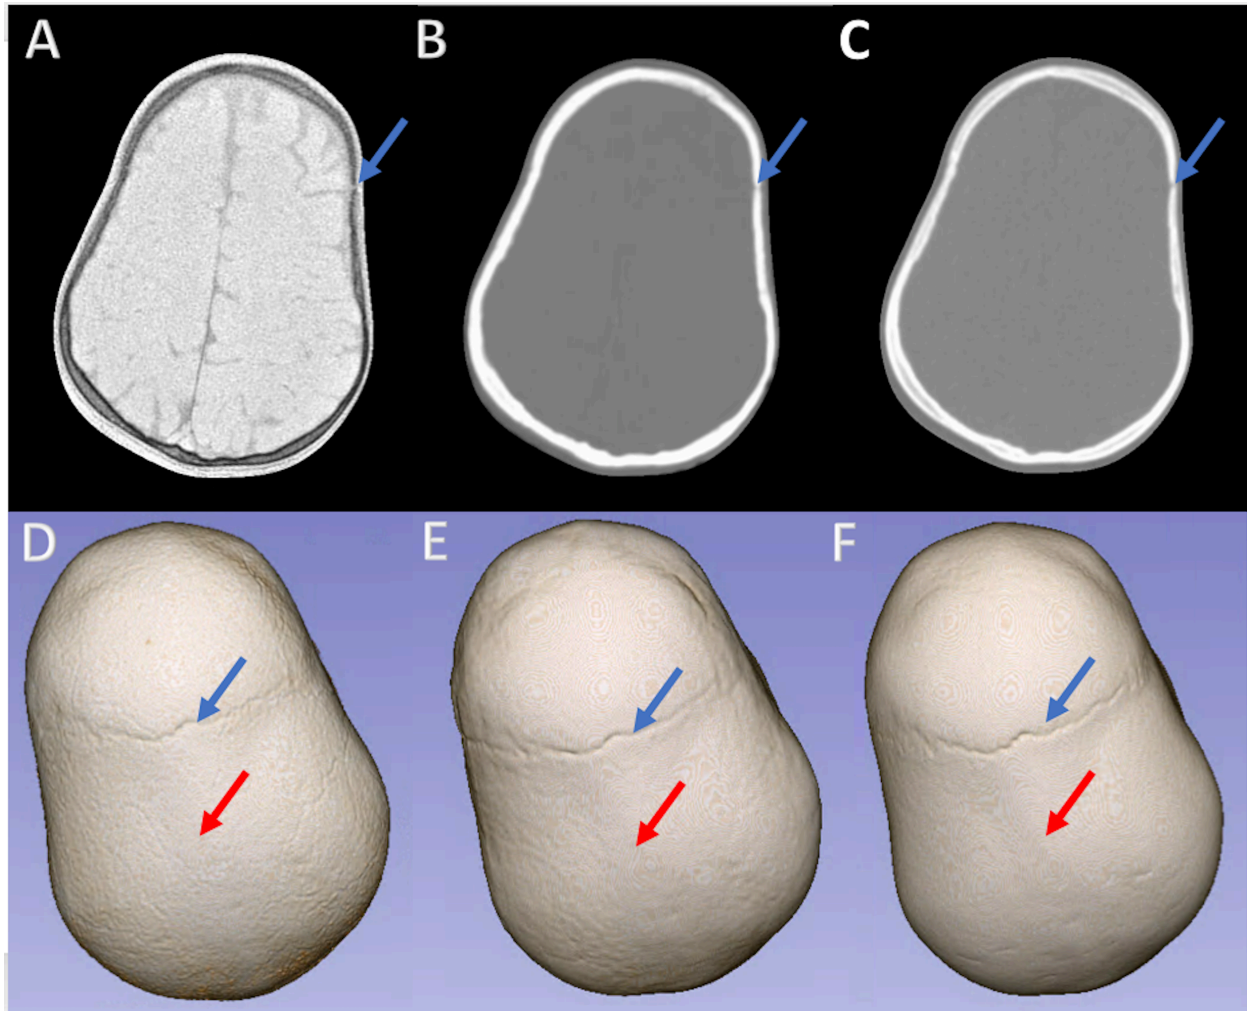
Representative MR (A), pCT<sub>Com</sub> (B), and CT (C) images from a craniosynostosis patient (1.8 year old, female), and the corresponding 3D surface rendered cranial bone images using iMR (D), pCT<sub>Com</sub> (E), and CT (F). Blue arrows indicate the presence of a coronal suture, and the red arrows indicate the absence of a sagittal suture.
